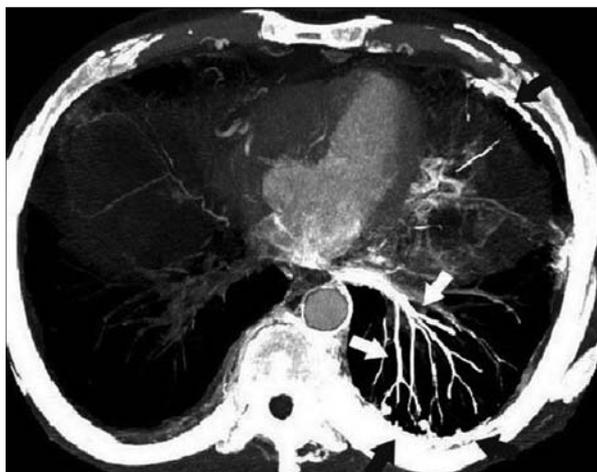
Transverse thick-slab maximum-intensity-projection CT image shows strong enhancement of the left inferior pulmonary veins (*white arrows*), and enhancing thickened pleura and peripheral bridging veins (*black arrows*).
